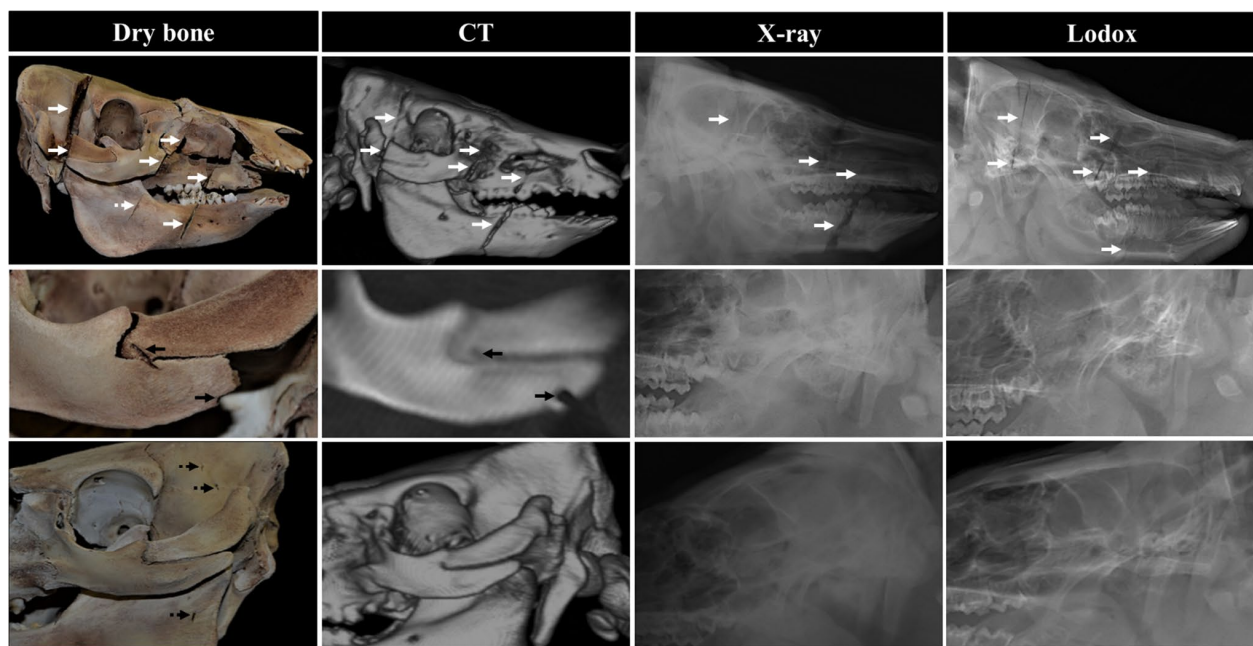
SFT defects to the skull, as seen on the dry bone, CT, X-ray, and Lodox. Many of the wide chop marks (solid white arrows) were identified by all imaging modalities, but some of the narrower, shallower chop defects (dashed white arrow) were only detectable on the dry bone. Some of the small, puncture defects as a result of stabbing
